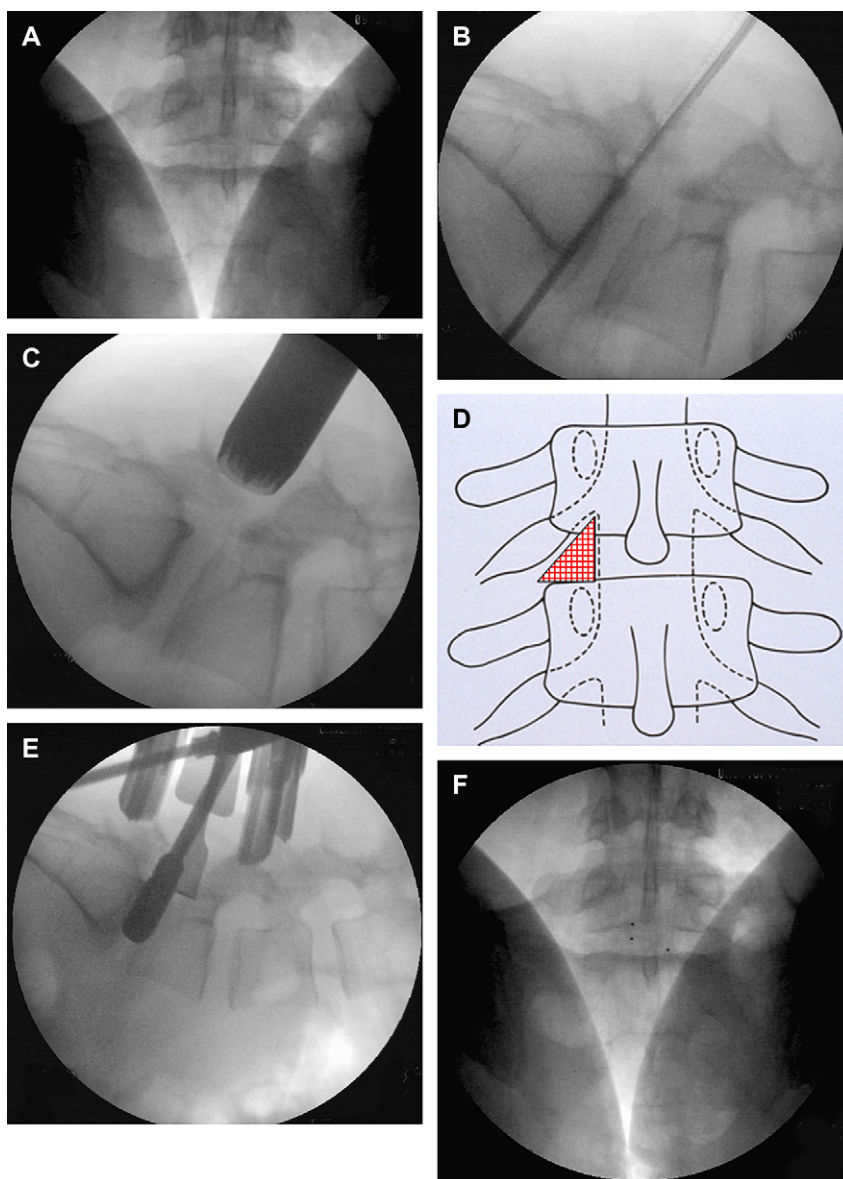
Intraoperative fluoroscopic images of the intervertebral disc of interest demonstrating an AP (*A*) and lateral (*B*) image. (*C*) Lateral intraoperative fluoroscopic image with the tubular retractor docked at the level of interest. Note that the tubular retractor is in line with the intervertebral disc of interest. (*D*) Working corridor for the TLIF bordered by the thecal sac medially, the exiting nerve root superiorly, and the pedicle wall inferiorly. (*E*) Insertion of a trial spacer before final cage placement can assist in (*F*, *G*) determining final implant dimensions. Note that the margins of the interbody cage are marked with three radiopaque beads to allow for radiographic determination of the final position of the implant. AP (*H*) and lateral (*I*) fluoroscopic images following a TLIF and placement of the percutaneous pedicle screws.
